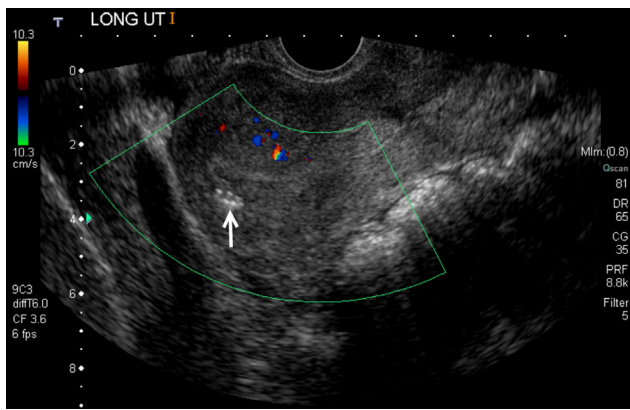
Echogenic lines are noted in the uterine fundus after deployment of gelfoam torpedoes (blue arrows). The flow in the fistula almost completely stopped on color Doppler.
